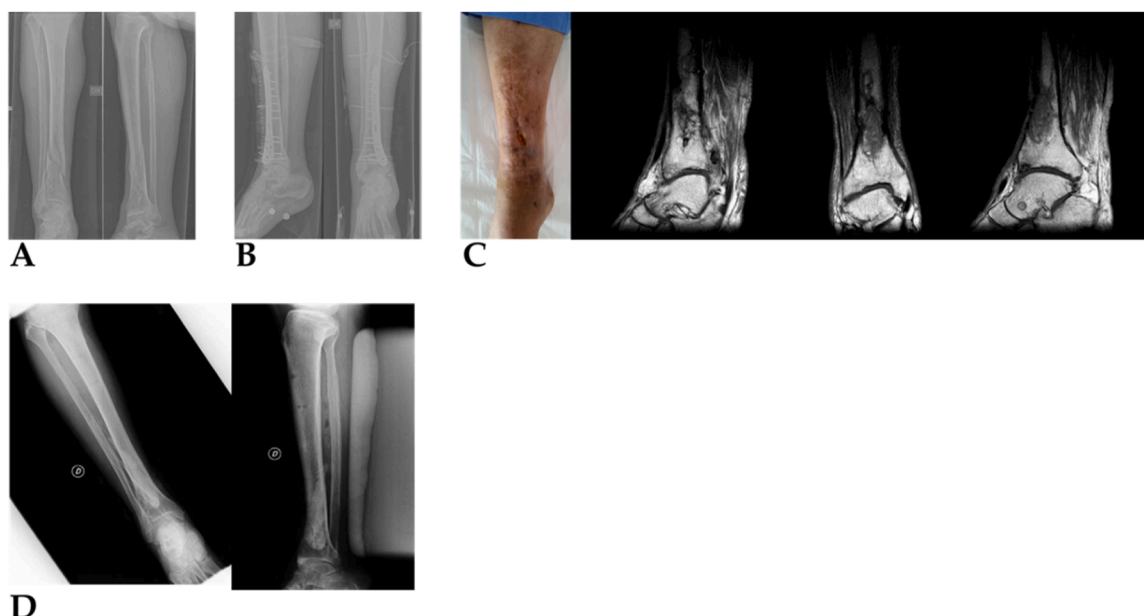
Before surgery (A) and after surgery (B). (C): At 5 months, a fistula with regenerative medicine for anterior bone sequestration, culture swabs positive for *Staphylococcus aureus*. (D): X-ray at about 6 months after anterior hemidiaphysectomy and drilling with Stimulan, medicated with specific antibiotics.
